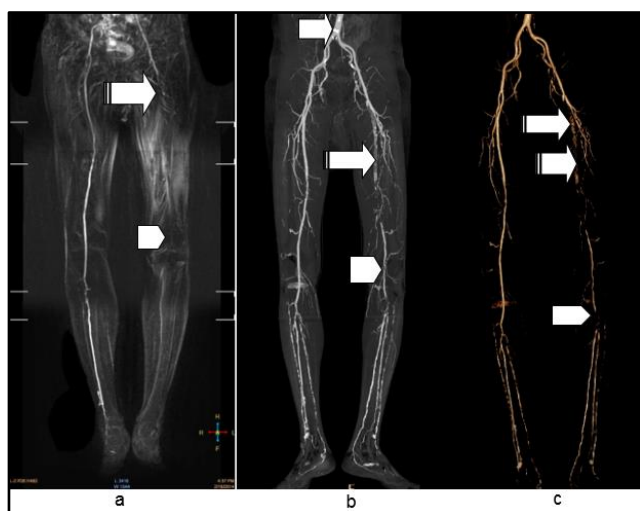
A) NE-MRA Image; B) & C) CTA Volume Rendered Image and MIP Image
